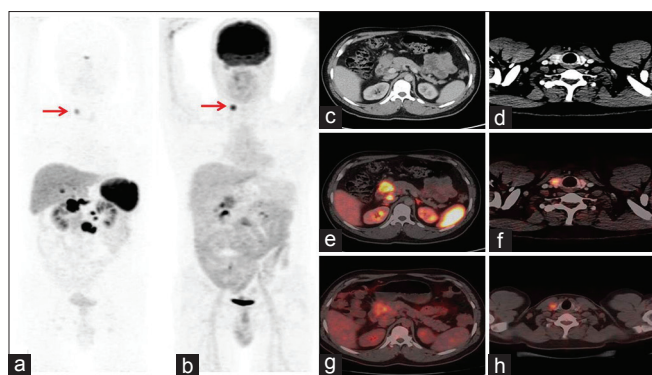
(a-h) Whole-body Ga-68 DOTANOC positron emission tomography/computed tomography and F-18 fludeoxyglucose positron emission tomography/computed tomography scintigraphy: Maximum intensity projection images, computed tomography, and fused cross-sectional images of the abdomen and thyroid region showed intense somatostatin avid tracer uptake in the primary site lesion, mesenteric lymph nodal mass, multiple hypodense liver lesions, and focal lesion in the right thyroid region (arrow). Mild fludeoxyglucose uptake is noted in the primary site lesion, mesenteric lymph nodal mass, and multiple hypodense liver lesions; however, right thyroid lobe nodule showed intense fludeoxyglucose uptake (arrow)
